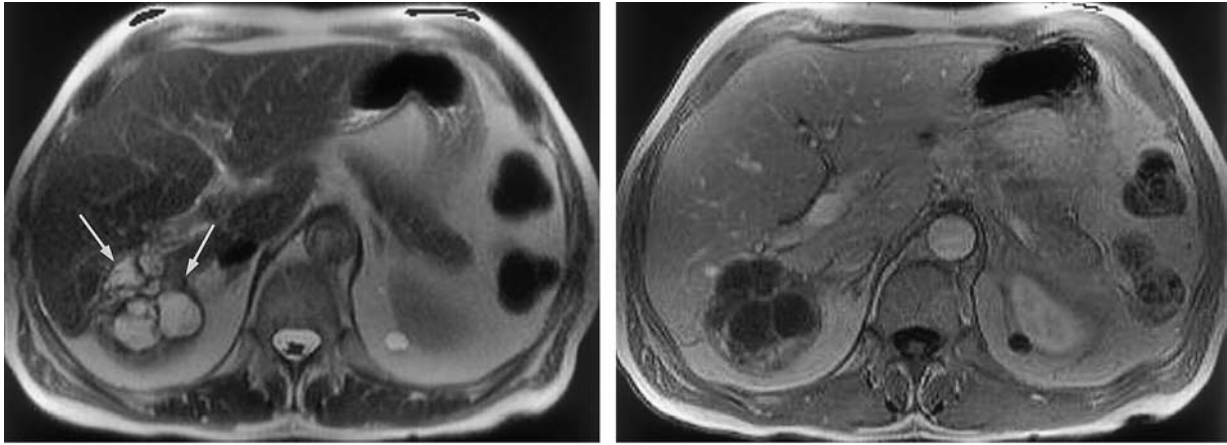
Biliary cystadenoma in a 49-year-old woman. (a) Fast spin-echo T2-weighted MR image shows a multilocular, septated mass (arrows) in segment 7 of the liver, with high signal intensity within the cystadenoma. (b) Corresponding portal-venous-phase gadolinium-enhanced T1-weighted MR image shows enhancement of the capsule and septa.
